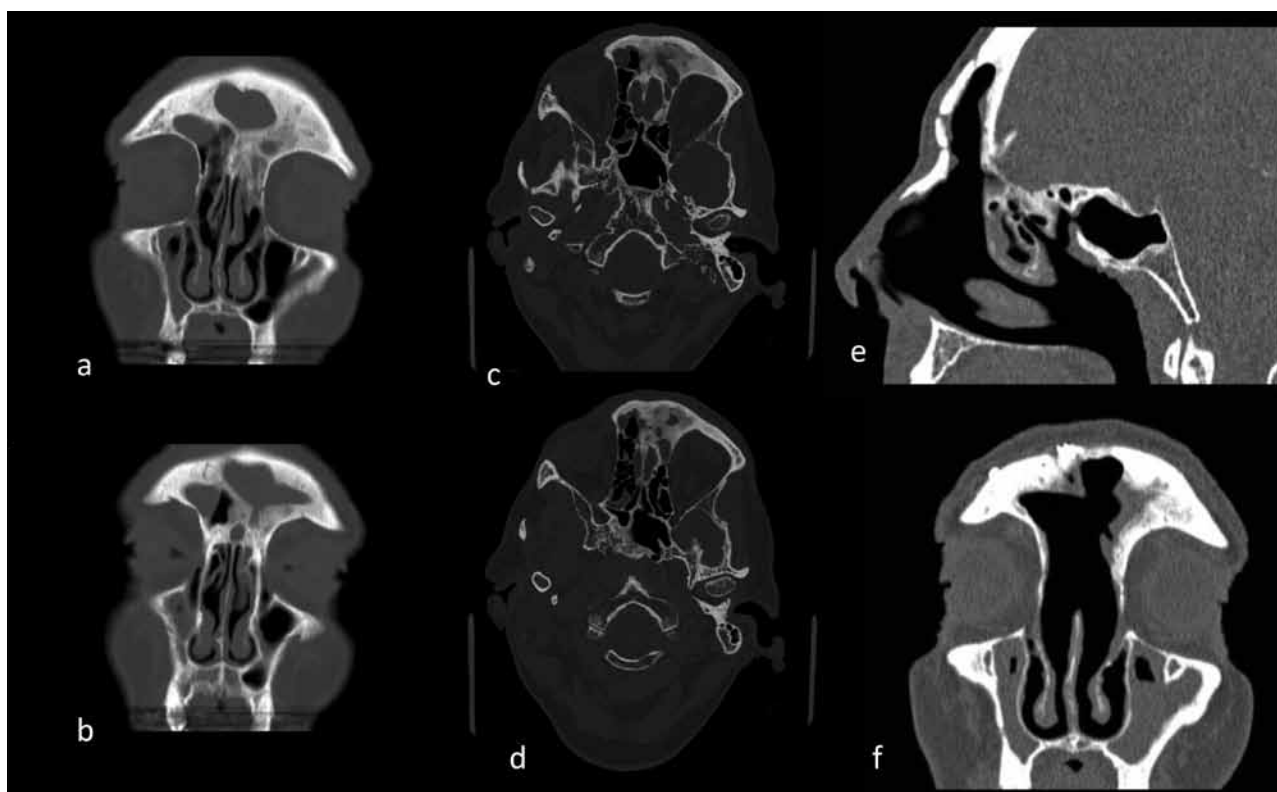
Neo-osteo-genesis of frontal sinus and recess with secondary frontal mucocele. a- d Axial and Coronal pre-op CT scans, e-f 12 months post-op OPF and endoscopic Draf III.
